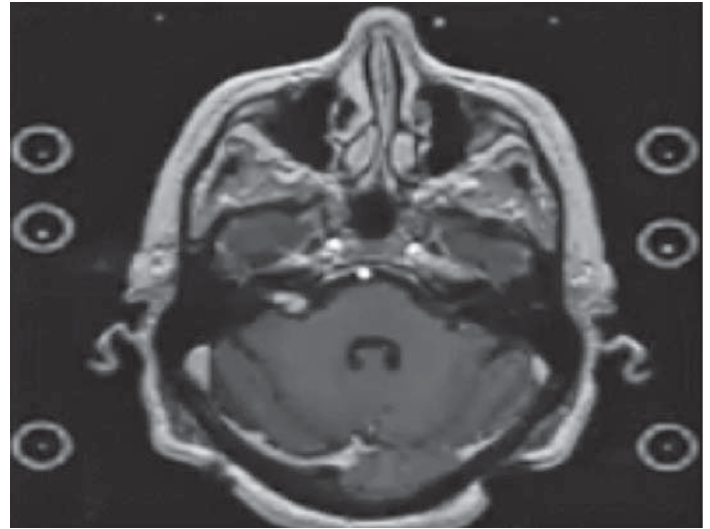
Fiducials from the localizer box are outlined in red circles on a representative MRI slice. Depending upon the location of each MRI slice, the location of the red circles will vary.
